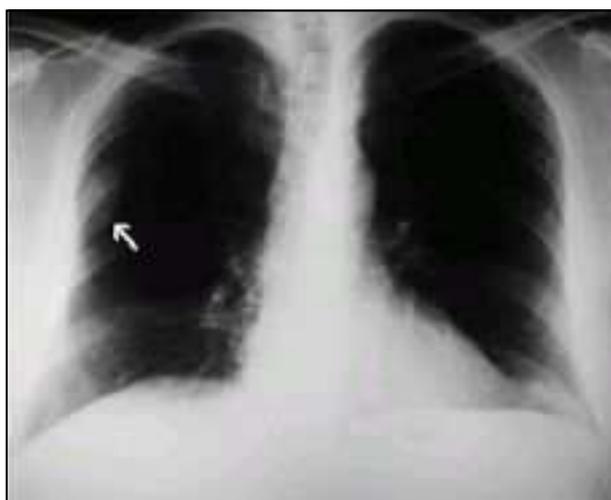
Chest radiograph showing fracture of the lateral arch of the right seventh rib and extrapleural hematoma (arrow).
